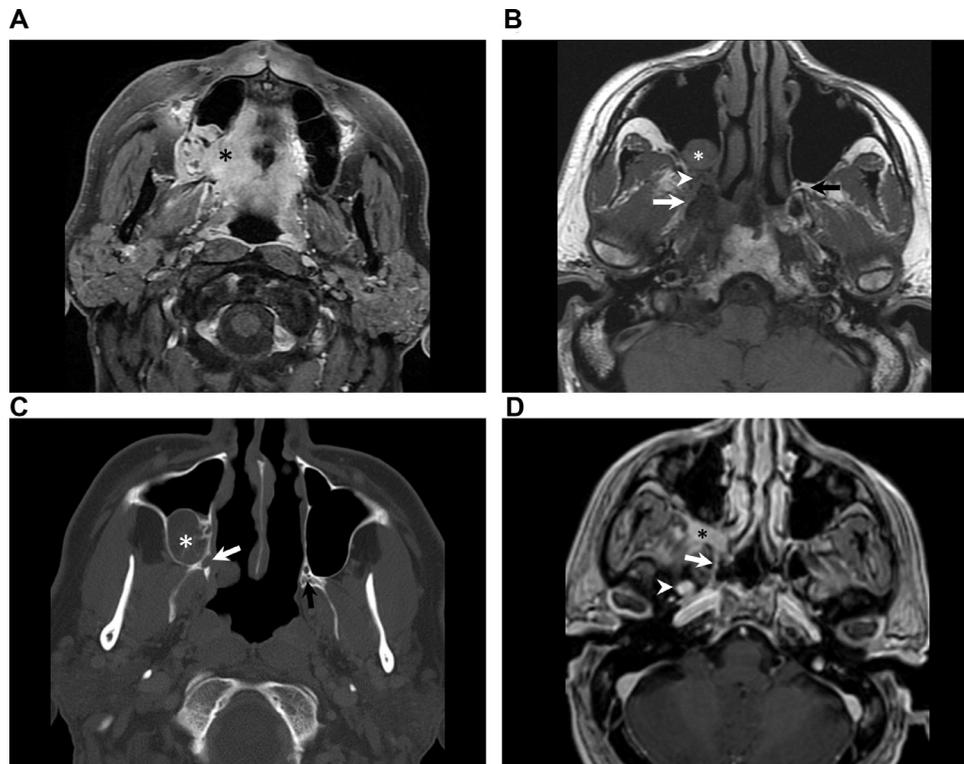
Right maxillary and hard palate adenoid cystic carcinoma with perineural spread along the palatine nerves to the pterygopalatine fossa and intracranially. (A) Axial T1-weighted postcontrast fat-saturated image. There is a large infiltrative enhancing biopsy proven adenoid cystic carcinoma arising from the right inferior maxillary sinus (black asterisk) and invading the hard palate and adjacent alveolus. (B) Axial T1 weighted image without contrast. Perineural tumor spread arising from the adenoid cystic carcinoma of the right inferior maxillary sinus (white asterisk) effaces the fat of the right pterygopalatine fossa (white arrowhead) via the palatine canals and infiltrates the right pterygoid plate (white arrow). Note normal T1 hyperintense fat signal in the left pterygopalatine fossa (black arrow). (C) Axial contrast-enhanced CT in bone window. The adenoid cystic carcinoma mass remodels the posterior right maxillary sinus (white asterisk). The right greater palatine canal (white arrow) is abnormally enlarged secondary to retrograde perineural tumor spread. Compare to this to normal sizes of the left greater and lesser palatine canals (black arrow). (D) Axial T1 weighted spoiled gradient fat-saturated image. There is extensive perineural tumor spread within the right pterygopalatine fossa (black asterisk), right vidian canal (white arrow), and right foramen ovale (white arrowhead).
